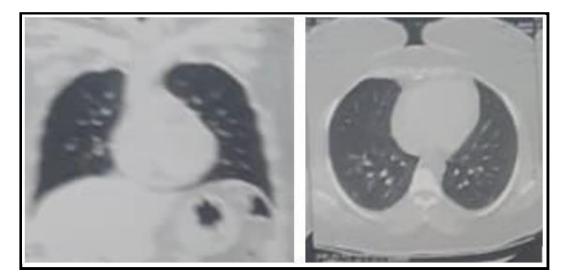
Ground glass appearance of both lungs on CT scan.
